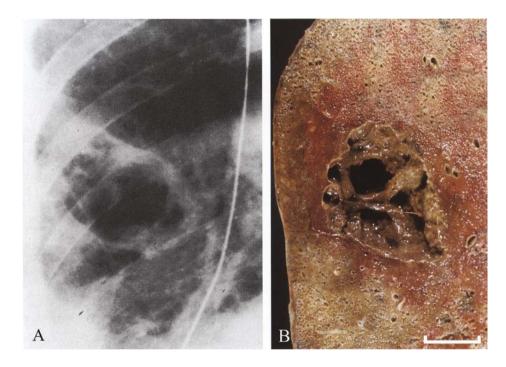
Acute abscess cavity. A. Chest radiograph shows cavity with loss of parenchymal detail internally from drainage of necrotic debris. Note variable thickness of reaction in surrounding lung. Radiodense line is radiographic marker on tube.
